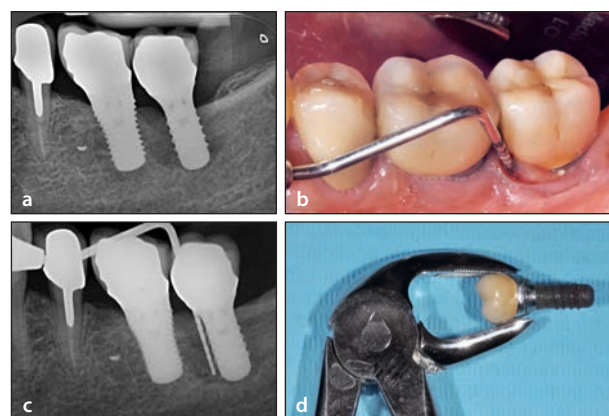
(a) Failing dental implant in the mandibular left quadrant. (b) Deep pocket probing with bleeding and suppuration. (c) Radiograph with a periodontal probe indicating defect depth. (d) Extracted implant.
